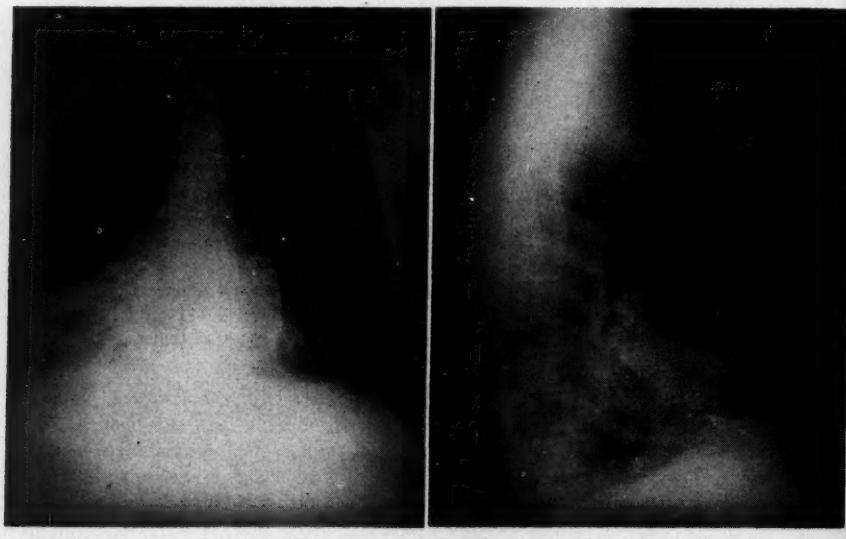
Posteroanterior (A) and lateral (B) chest x-rays taken in 1954, showing extensive calcification of the pericardium.
